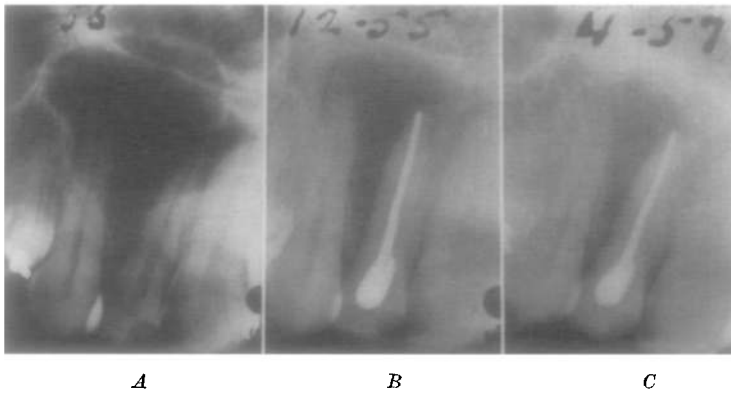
A, Diagnostic roentgenogram of extensive periapical and interradicular rarefaction between lateral incisor and cuspid teeth. Note displacement of roots. *B*, Seven months following insertion of tube drain and 6 months following completion of endodontic therapy. *C*, Twenty-three months after treatment. Note resolution of rarefaction and repositioning of roots.
